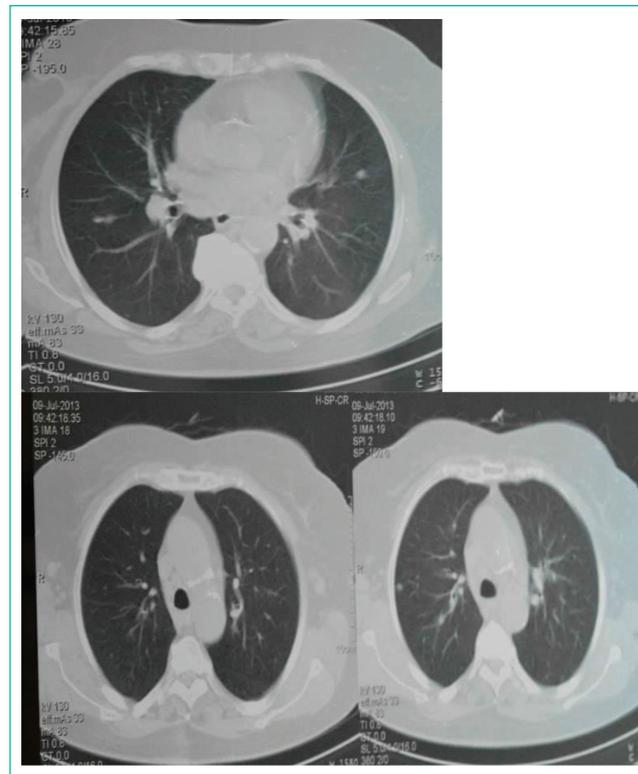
Chest CT scan: Sub-carinal and Para-aortic nodes.
